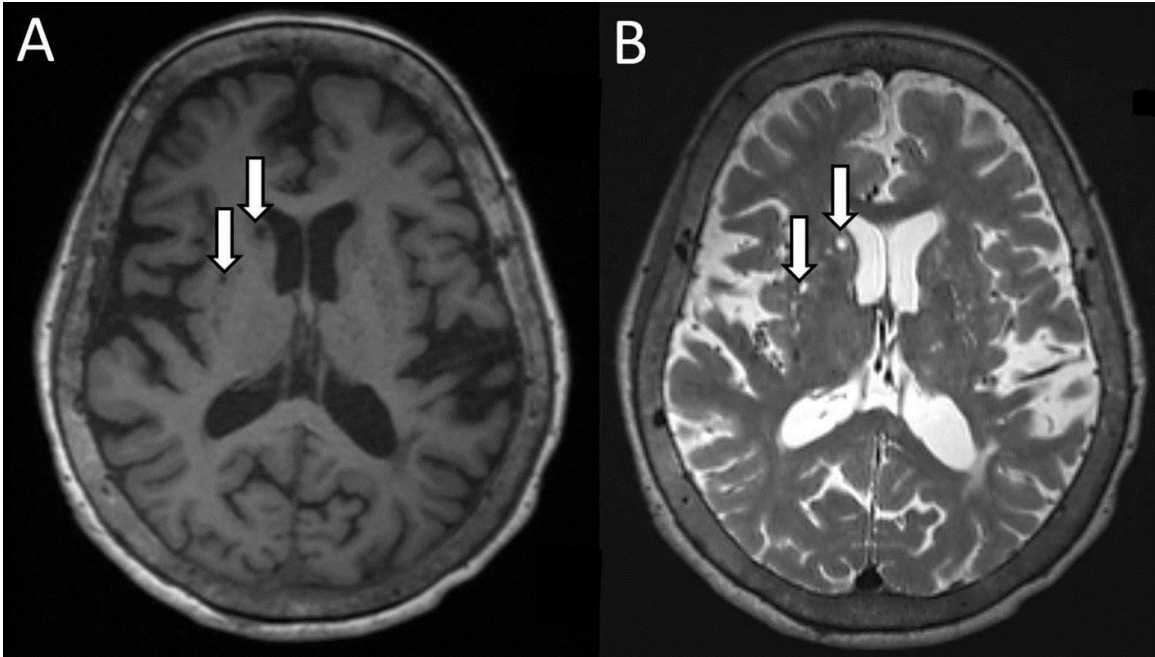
Paravascular Virchow-Robin spaces depicted on MRI. Axial non-contrasted brain MRI demonstrating perivascular spaces (arrows) that appear hypointense to brain tissue and isointense to CSF in T1-weighted (A) and T2-weighted (B) sequences.
